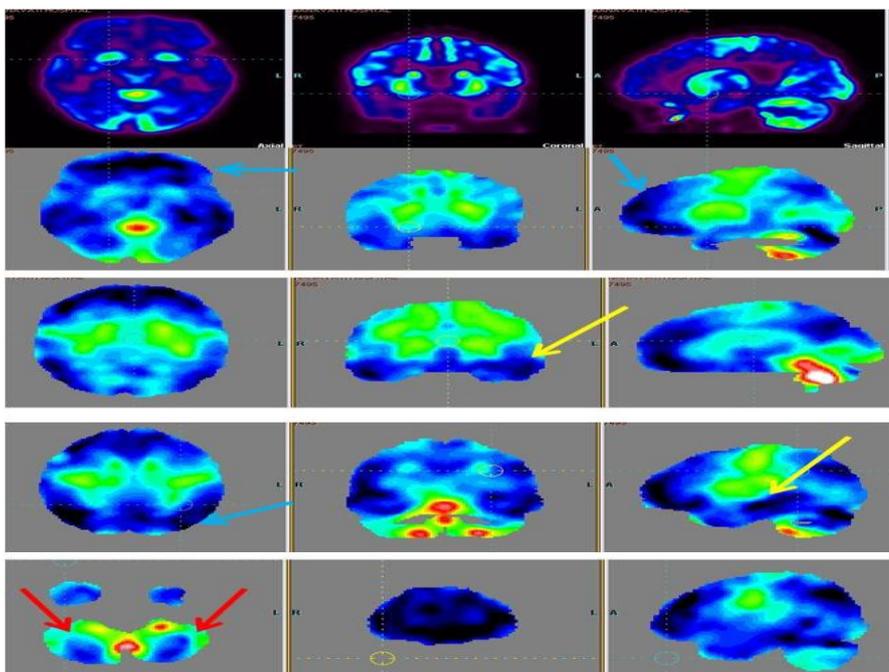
18FDG PET in a 4 year old autistic boy shows reduced FDG uptake in frontal, parietal and occipital lobes (blue arrows), mesial temporal structures (yellow arrows) and cerebellum (red arrows).
